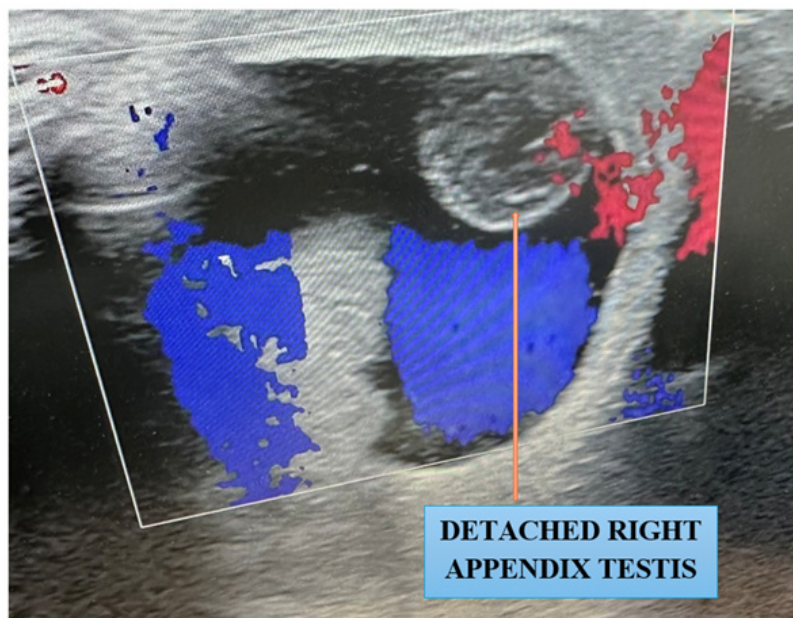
A color Doppler Ultrasound of the scrotum showing the detached right appendix testis which appears avascular with no blood supply.
